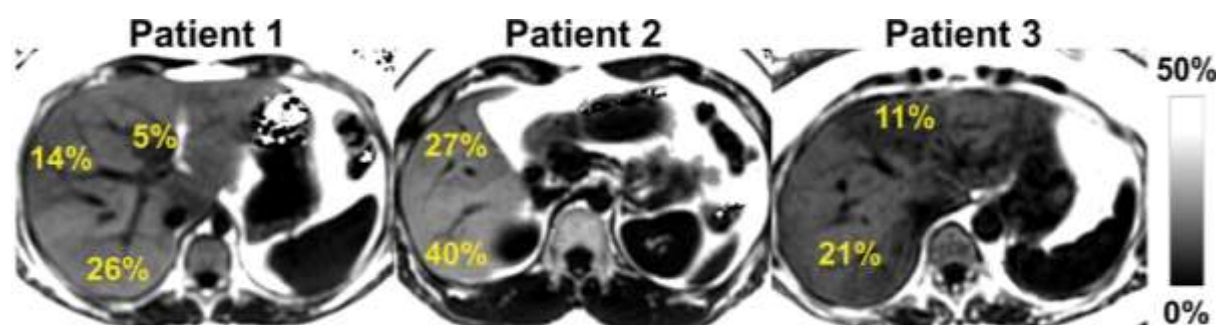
Representative cases. Patient 1- 51 year old male, Patient 2 – 57 years old male with DM, Patient 3 – 42 year old male with no h/o DM. Showing Chemical shift–encoded (CSE) MRI assessment of fat content over the entire liver. 3- dimensional CSE MRI proton density fat fraction (PDFF) maps in three different patients with heterogeneous pattern of steatosis.
